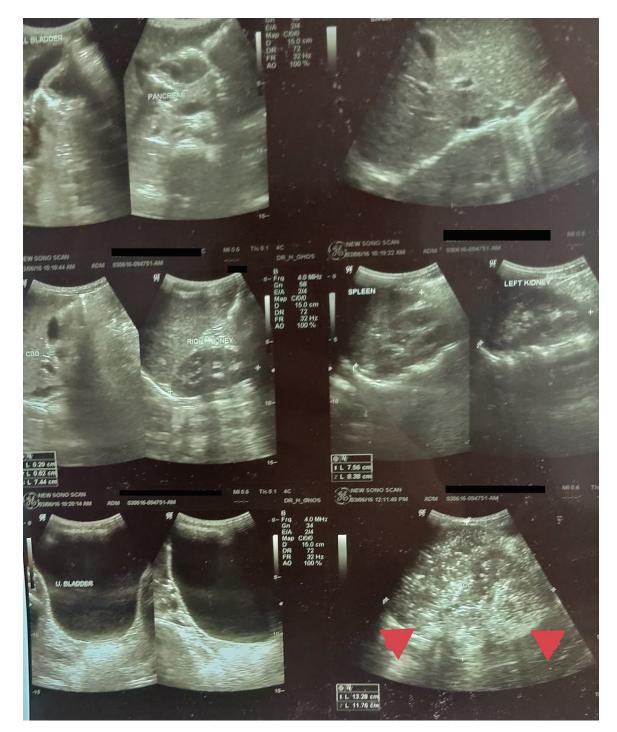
Ultrasound scan of abdomen of the 12-year-old patient. The red arrowheads indicate an area of increased echogenicity suggestive of a space-occupying lesion. The other organs appear normal.
